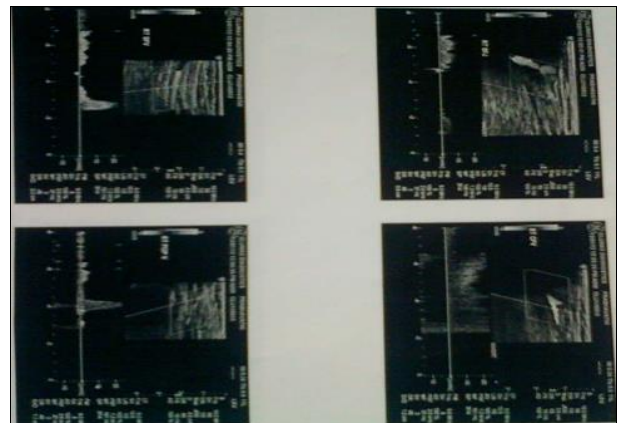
Normal study of Venous Doppler of Lower Limbs
